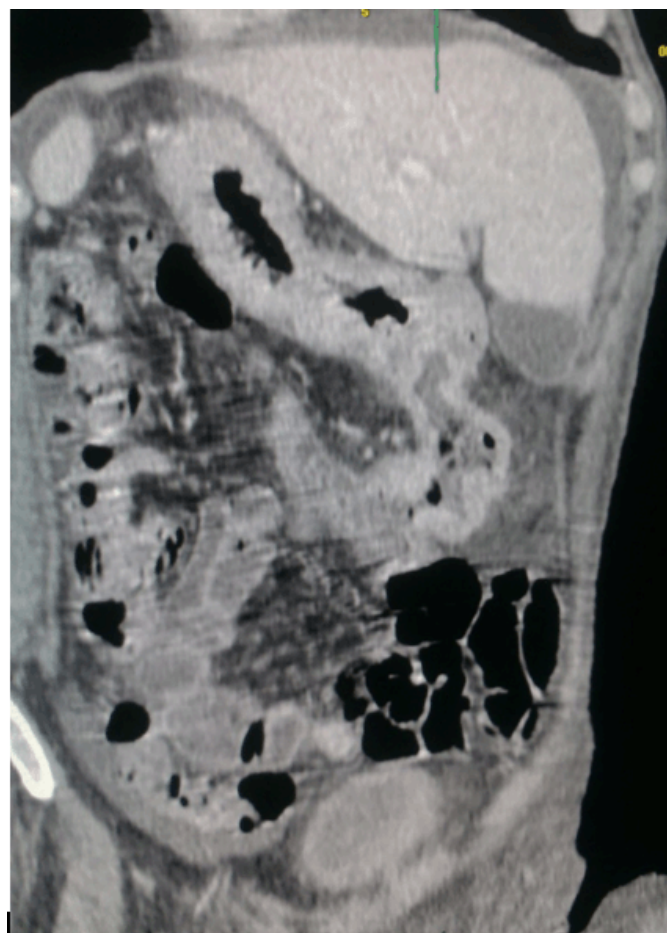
Abdominal computed tomography scan (coronal reconstruction) showing situs inversus with dextrocardia signs and a lesion at the gastric antrum.
